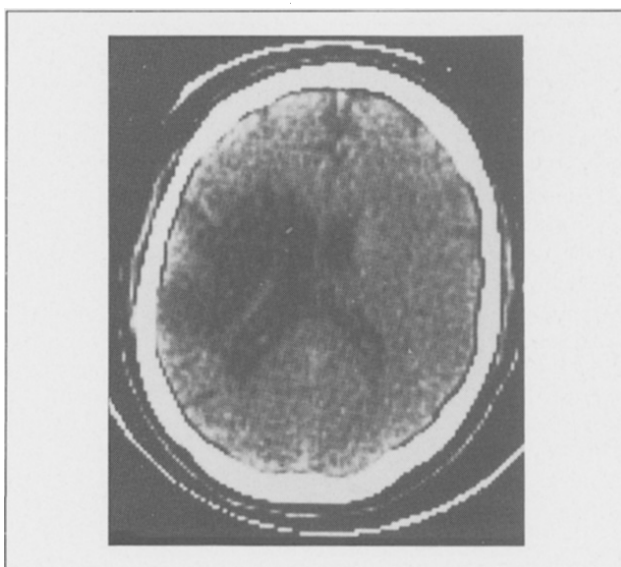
CT scan of Case 2 shows bilateral parietal lesions.
